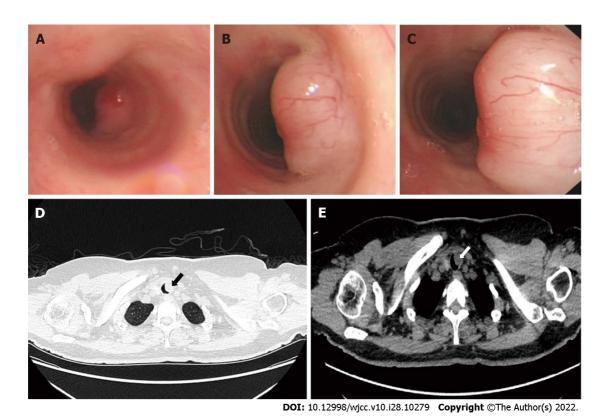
Bronchoscopic view and computed tomography scan of the chest showing the tracheal tumor. A-C: Three different observation positions were observed during bronchoscopy: Distant (A), middle (B), near (C); D: Computed tomography (CT) scan, lung window; E: CT scan, mediastinal window.
